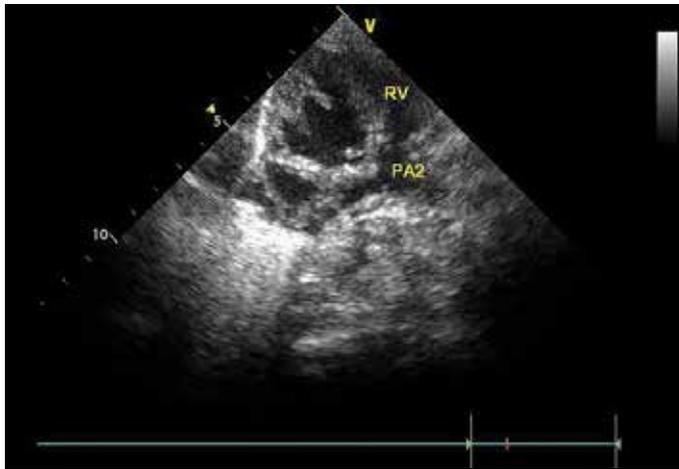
Echocardiogram showing pulmonary artery-2 connecting the right ventricle
